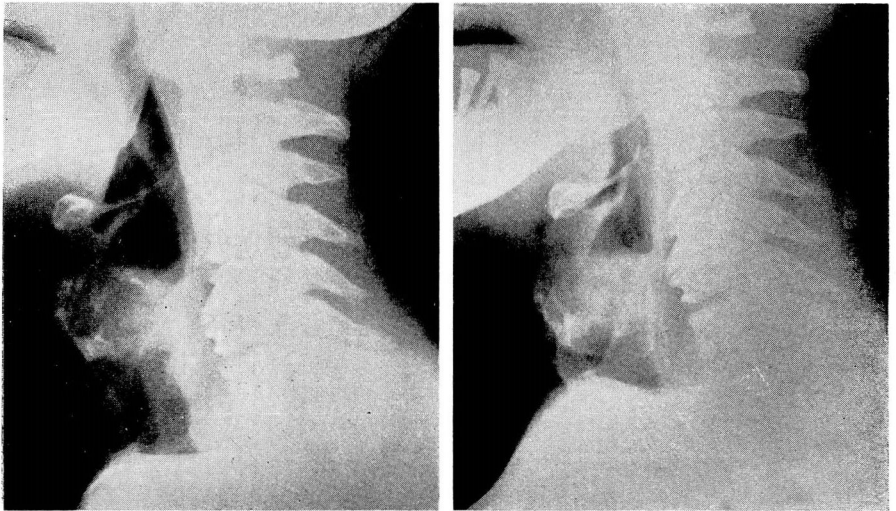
Lateral roentgenograms of neck showing tumor mass in larynx.
